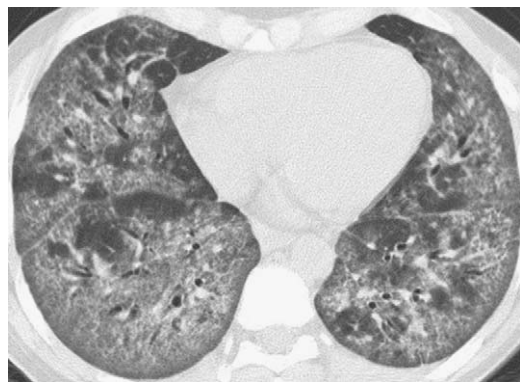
Ground-glass opacity on HRCT imaging: potentially reversible pulmonary inflammation. Axial HRCT image shows basilar, posterior-predominant ground-glass opacity in a patient with collagen vascular disease. Some traction bronchiectasis and reticulation is present, but the amount of ground-glass opacity is far in excess of the findings suggesting pulmonary fibrosis. Surgical lung biopsy showed nonspecific interstitial pneumonitis.
